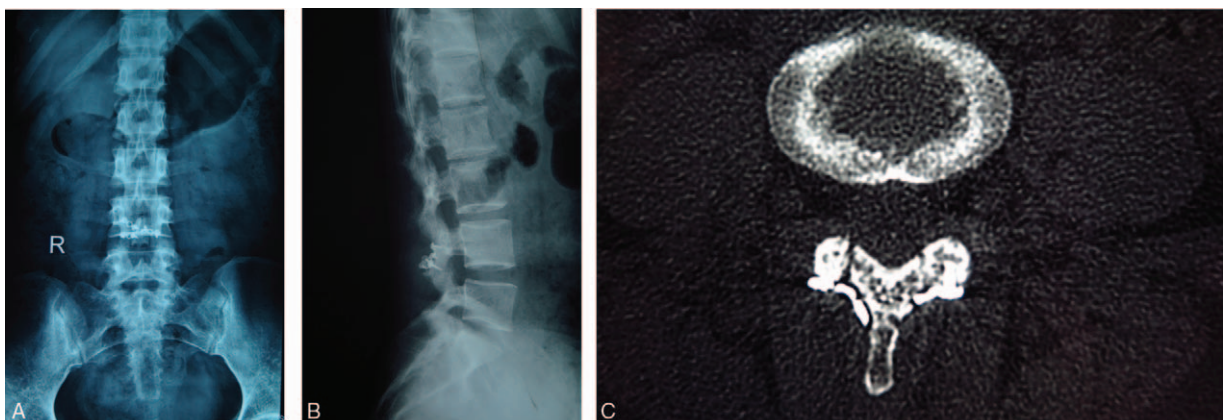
Three-month postoperative x-ray and CT scan. Three-month postoperative anteroposterior x-ray (A). Three-month postoperative lateral x-ray (B). Three-month postoperative CT scan shows 2 clear bone cracks (C). CT=computed tomography.
